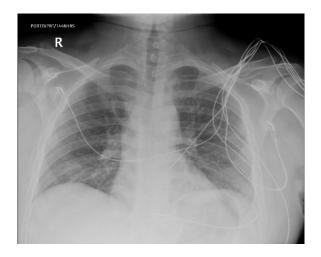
Chest x-ray reveals ill-defined patchy parenchymal densities over the lower lobes suggest evolving multifocal pneumonia or atypical viral pneumonia.
